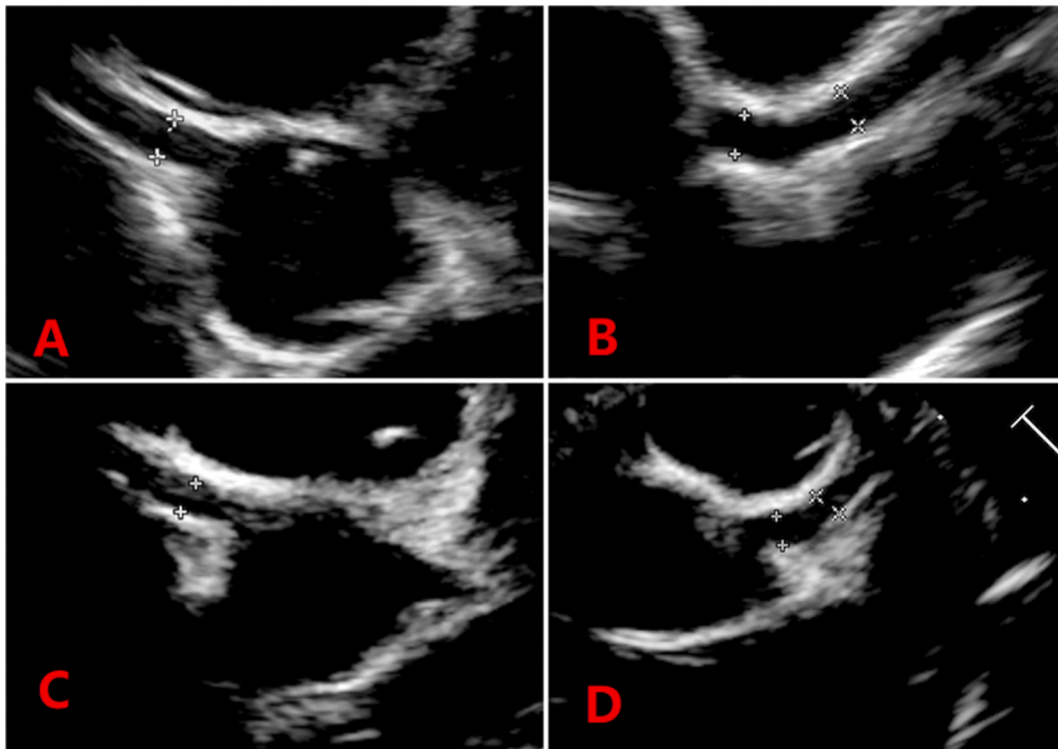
A, right coronary artery aneurysm (CAD) with a z-score of 3.8 (diameter, 3.40 mm) was found on cardiac echocardiography at the 28th day. B, left main coronary artery (2.55 mm) and left descending artery (1.90mm) with normal diameter at the 28th day. C, diameter of right coronary artery aneurysm came to normal level (2.50 mm; z-score, 1.4) at the 42nd day, and with normal LCA (2.50 mm) in picture D.
